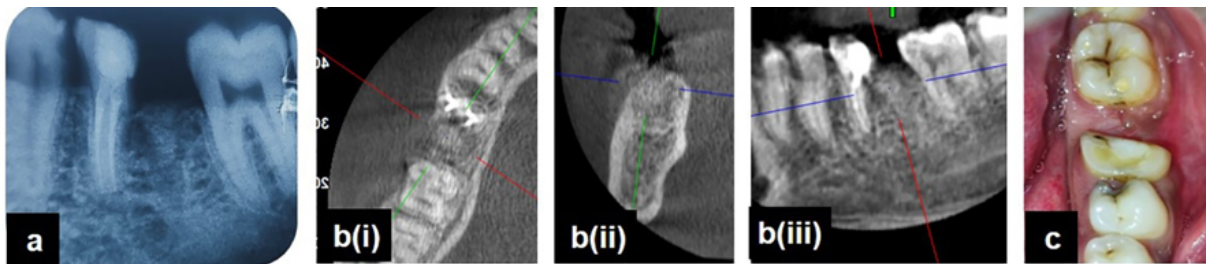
1-month follow-up: (a): Periapical radiograph, (b): CBCT views; i): Axial; ii): Coronal; iii): Sagittal, (c) Clinical view.
